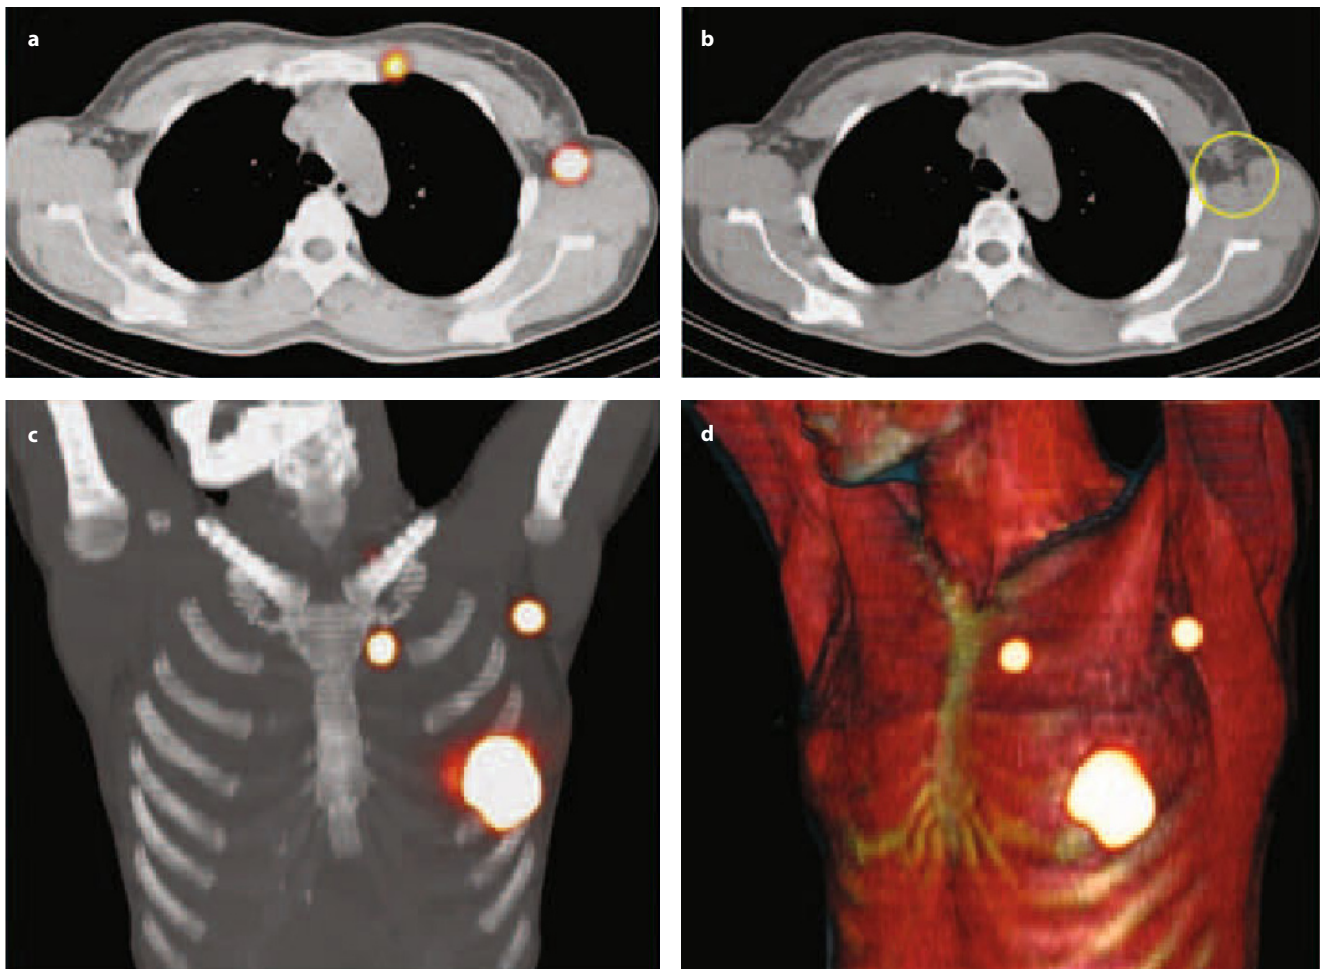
Patient with breast cancer. a Fused axial SPECT/CT section obtained during lymphoscintigraphy, showing two SLNs, respectively in the left internal mammary chain and in the left axilla. b The *yellow circle* corresponds to a small lymph node seen on axial CT. c Fused coronal SPECT/CT displayed as a maximum intensity projection, showing a SLN in the left axilla and an internal mammary chain sentinel node in the second left intercostal space. d SPECT/CT with volume rendering for 3D display, showing the two SLNs, respectively in the left internal mammary chain and in the left axilla, with their anatomic localizations with reference to muscles and bones
